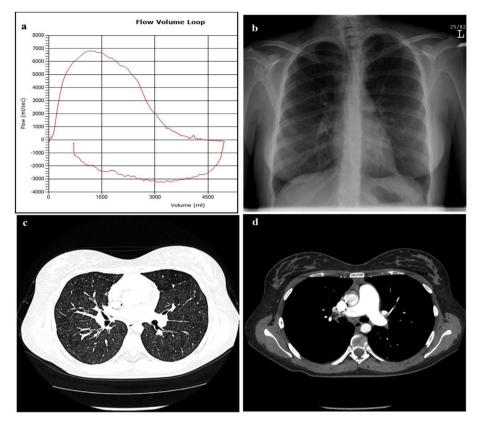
a. Flattening of inspiratory flow volume loop; b. CXR with interstitial changes in lung bases; c,d. CT Chest with ground-glass opacities (c) and air-trapping and enlarged pulmonary artery (d).
